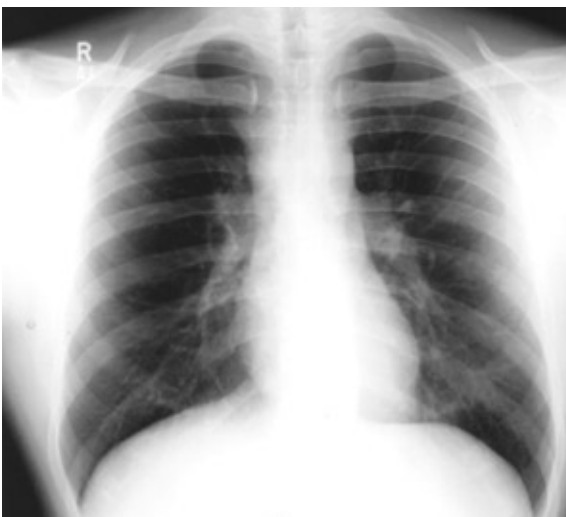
Repeat chest radiograph taken three months later shows clearing of the effusion.
